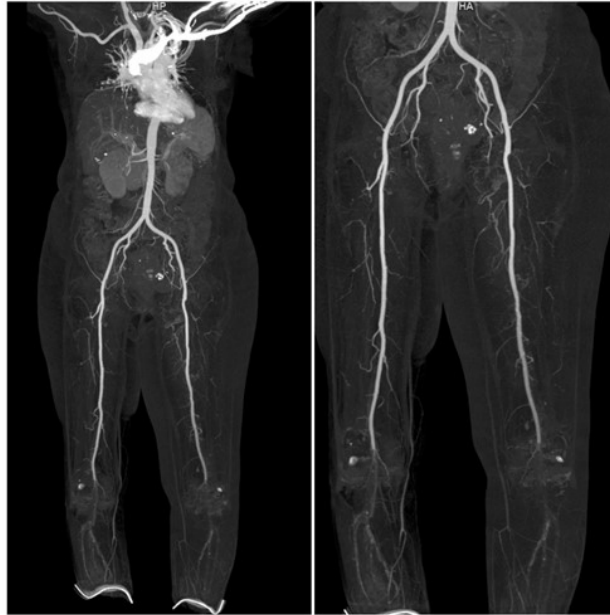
CT peripheral angiogram in both lower limbs showing complete occlusion of bilateral popliteal arteries, bilateral anterior and posterior tibial arteries upto the level of stump with few adjacent collaterals from thigh.
